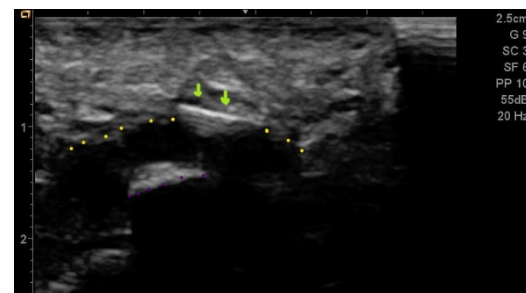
Ultrasound- guided Plantar fascia injection. yellow dots: plantar fascia, violet dots: calcaneus, green arrows: needle.
